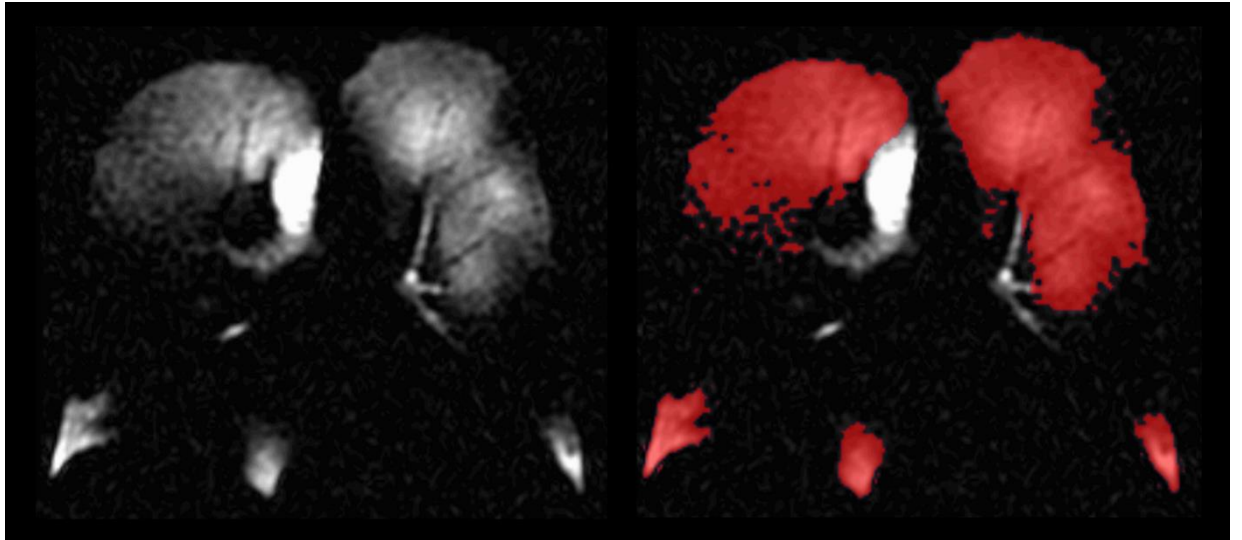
A coronal slice of a ^3He MRI intensity (left) along with a fused binary segmentation (right) which was manually edited to exclude the trachea and large airways.
